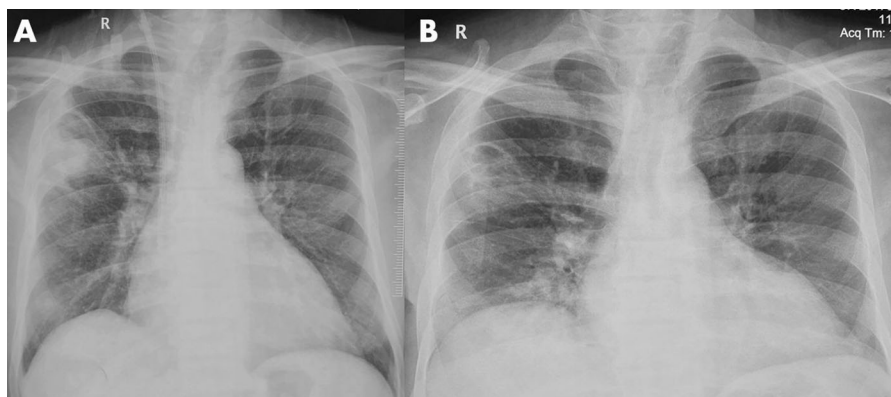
Chest radiograph performed at discharge A and after completing amphotericin therapy B showed significant resolution of the right upper zone cavity
